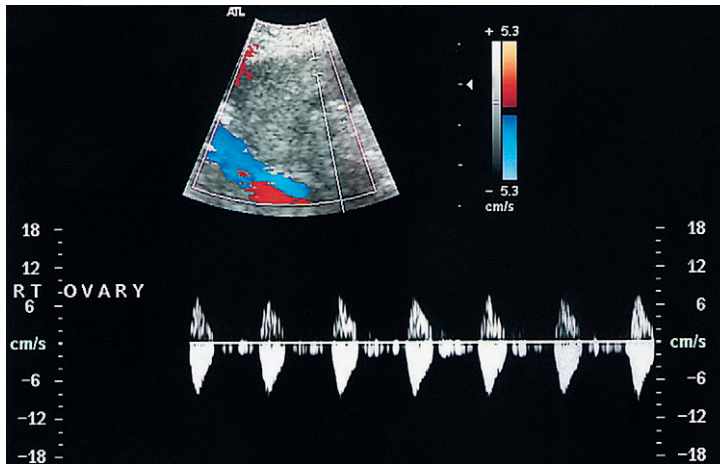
Spectral Doppler of a postmenopausal ovary showing no diastolic flow. Some artefactual flow is demonstrated in both systole and diastole due to the small size of the vessels sampled.
